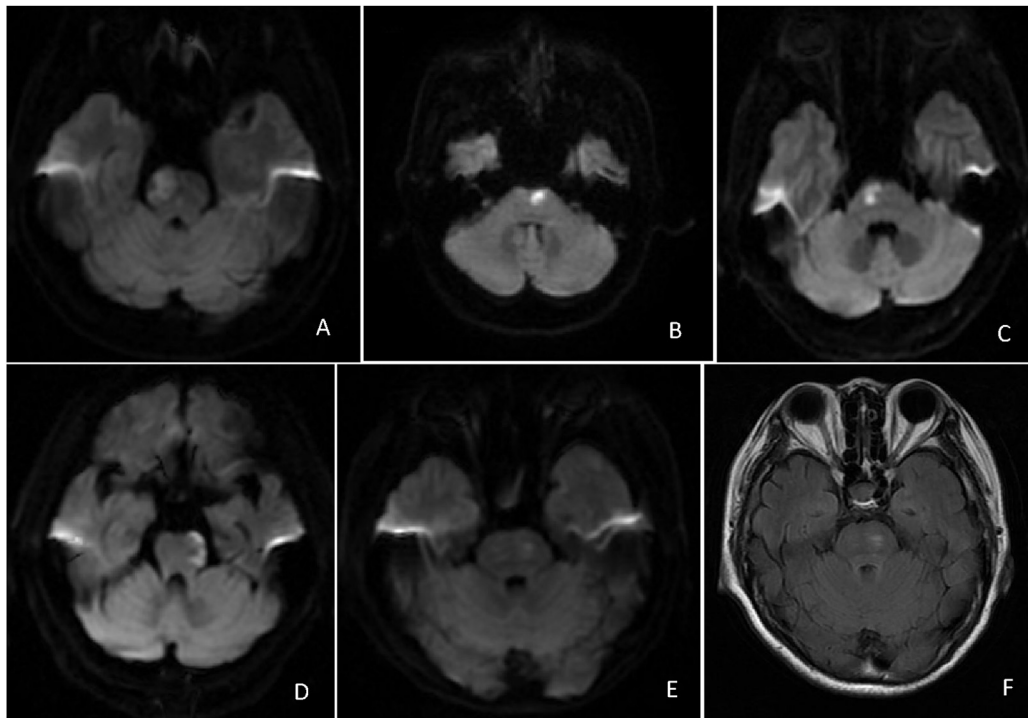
Magnetic resonance imaging of the patients with pontine infarction and RLS. Axial diffusion-weighted brain MRI showing focal hyperintensity in the right pons of Case 1 (A) and Case 3 (C), in the left pons of Case 2 (B) and 4 (D) and 5 (E), and axial FLAIR MRI of Case 5 (F). RLS: restless leg syndrome; FLAIR: fluid-attenuated inversion-recovery.
